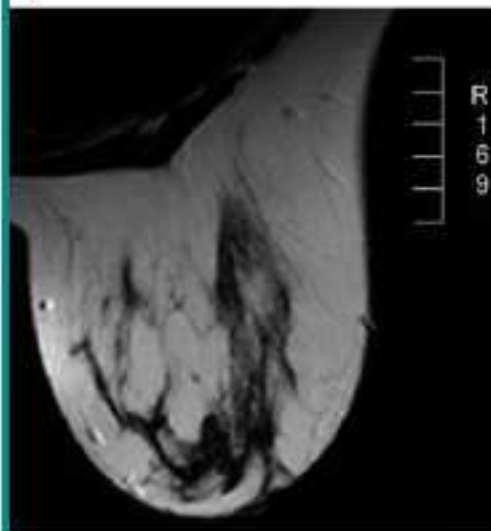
True volume of dense tissue cannot be accurately measured on 2D images without information on exposure values and breast thickness. Breast appears moderately dense on (a) MLO and (b) CC mammographic projections. (c) On transverse T2-weighted magnetic resonance (MR) image (repetition time, 5000 msec; echo time, 105 msec), fibroglandular tissue ("black" tissue) actually forms a shell around fat ("white" tissue) in center of right breast, and the breast is predominantly fat.
